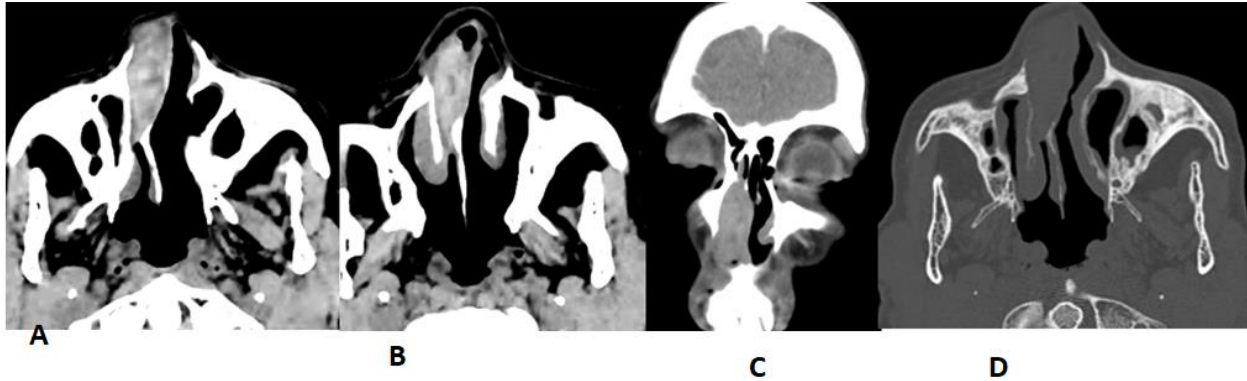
Post contrast Axial and coronal soft tissue window (A, B&C) and axial bone window CT of a patient who presented with blackish right nasal cavity mass. There is hyper attenuating right nasal cavity soft tissue mass that has eroded the right nasal bone, the wall of right nasolacrimal duct, inferior turbinate and has soft tissue extension to the anterior nasal soft tissue with overlying skin infiltration. Biopsy show malignant melanoma of the nasal cavity.
